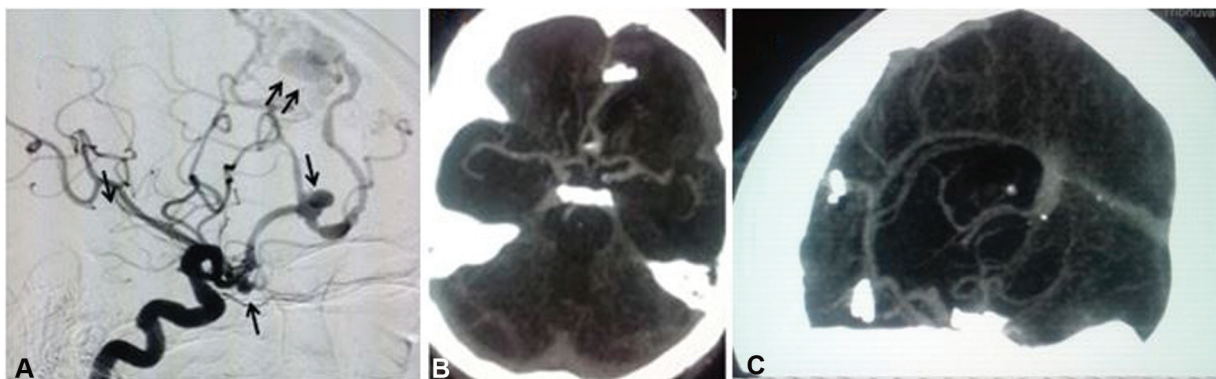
Cerebral angiogram of the patient (A) with ACoM and DACA aneurysms (*single arrow*) and an AVM (*double arrows*). Postoperative CT angiography (B, C) showing complete obliteration of aneurysms and excision of the AVM. ACoM, anterior communicating artery; AVM, arteriovenous malformation; CT, computed tomography; DACA, distal anterior cerebral artery.
